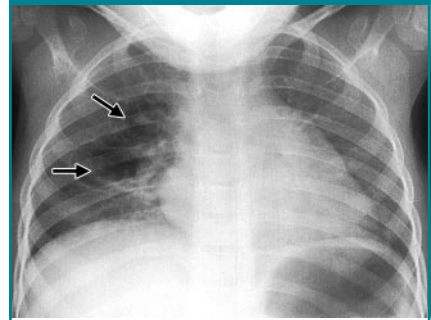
Chest radiograph shows a pneumatocele (arrows).
